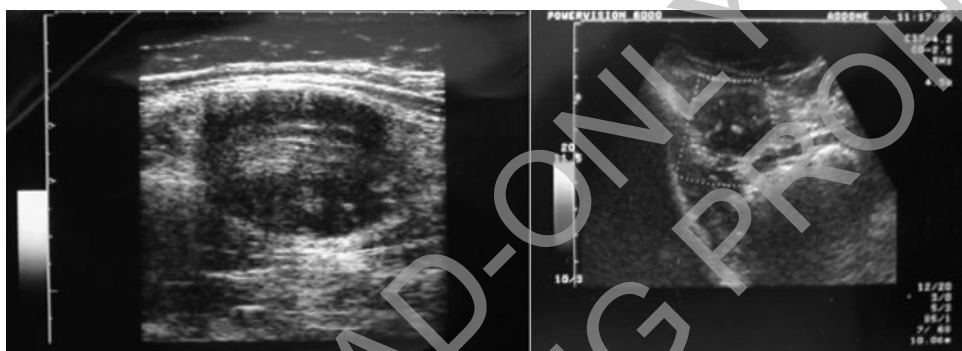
Ultrasound scan shows a large hypoechoic mass located in the rectus abdominis muscle.
